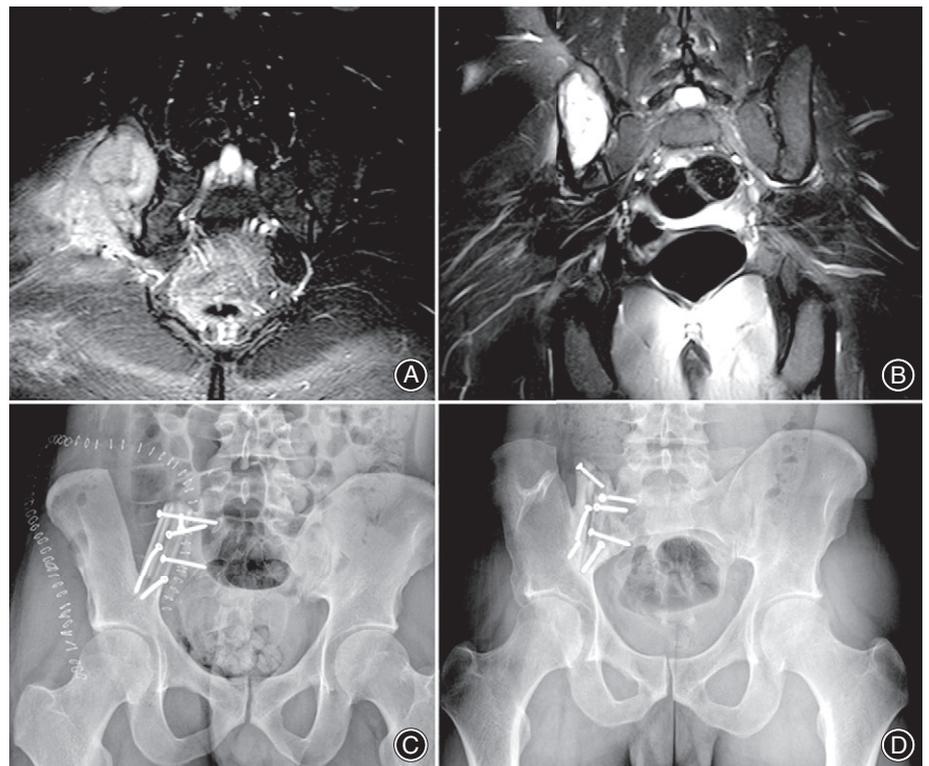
Example of the use of autografts to reduce complication rates in difficult locations like the pelvic ring: 19-year-old boy with a Ewing sarcoma of the pelvis (sacroiliac joint) resected and reconstructed by autograft: (A) Pelvic MRI at diagnosis. (B) MRI after neoadjuvant chemotherapy showing a very good response to neoadjuvant chemotherapy. (C) Postoperative X-ray film showing reconstruction of the pelvic ring with autologous fibula (x2) and screws. (D) Current X-ray film 4 years postoperatively. Despite some screws having broken, the grafts have healed. The patient is completely asymptomatic and is unrestricted in his sports activities.
